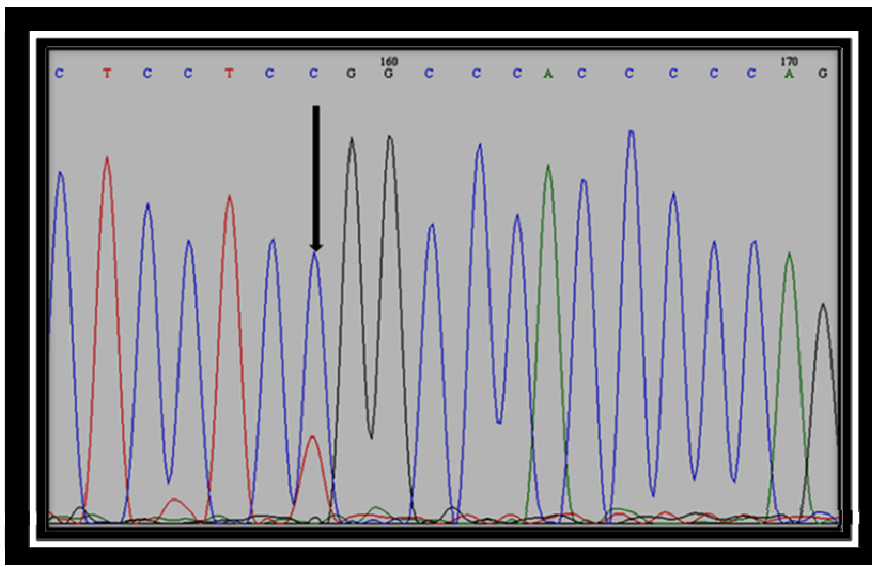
1426 C/T SNP genotyping by DNA sequencing. The chromatogram shows both C and T nucleotide peaks in CT genotype.
